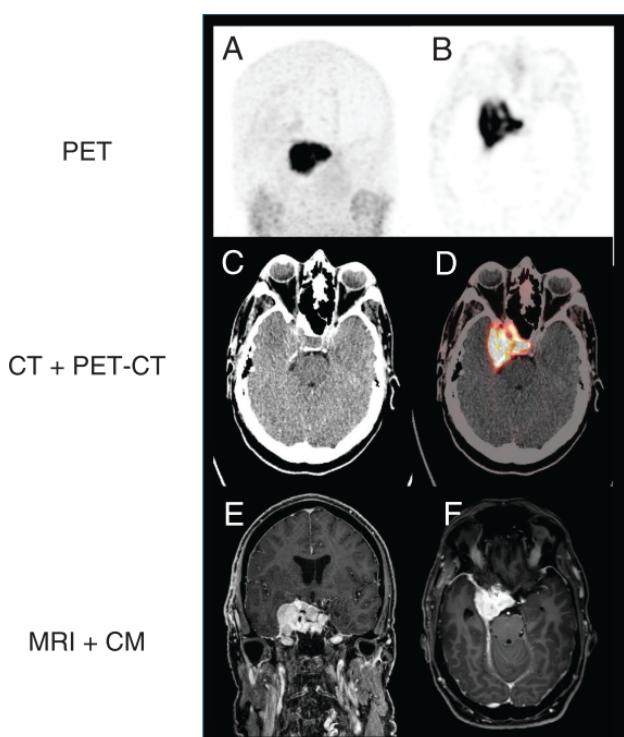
PET CT and MRI of meningioma.¹⁰
